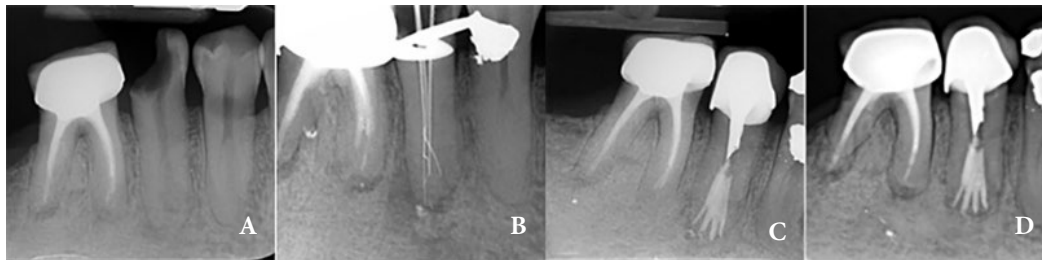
A) Pretreatment periapical radiograph of mandibular right second premolar; B) Working length determination radiograph; working length determination was done by #10 K file; C) Postoperative radiograph shows four canals in the apical third region; D) follow-up radiograph after two years
